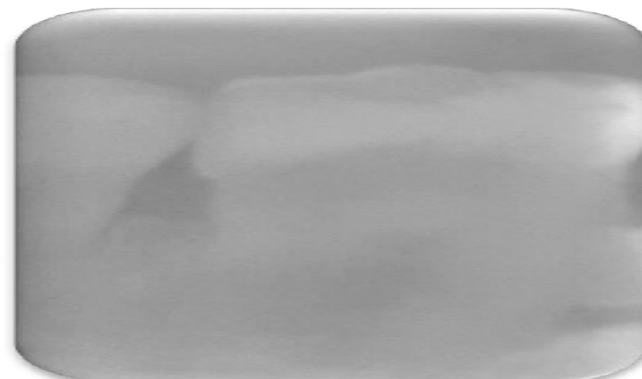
Initial radiography of the 46
